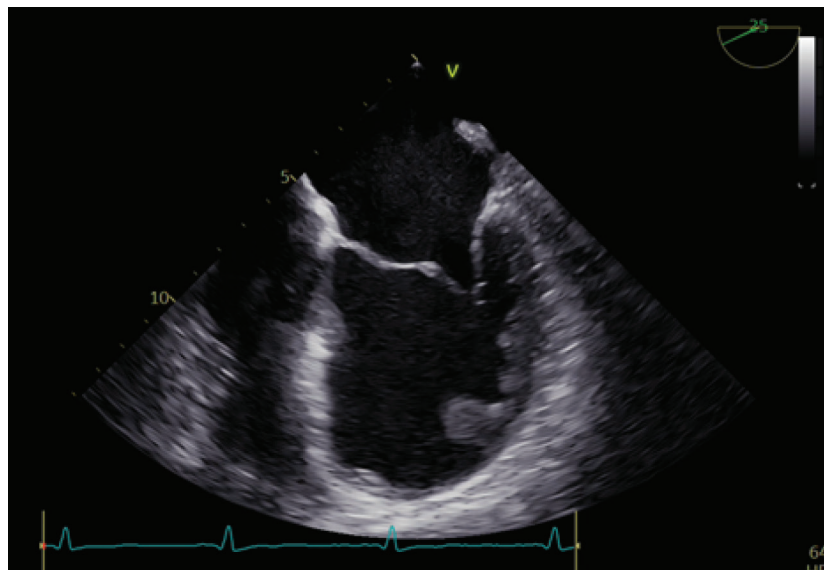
Left ventricular tumor on transesophageal echocardiography.
